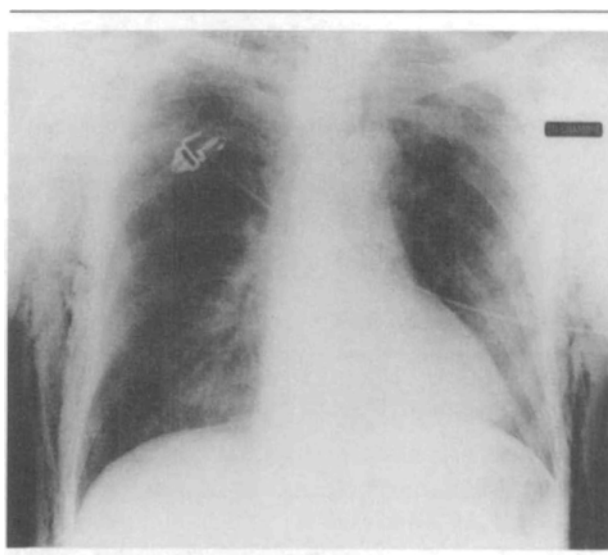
FIGURE Chest x-ray after extubation. Note subcutaneous emphysema round the chest wall.
